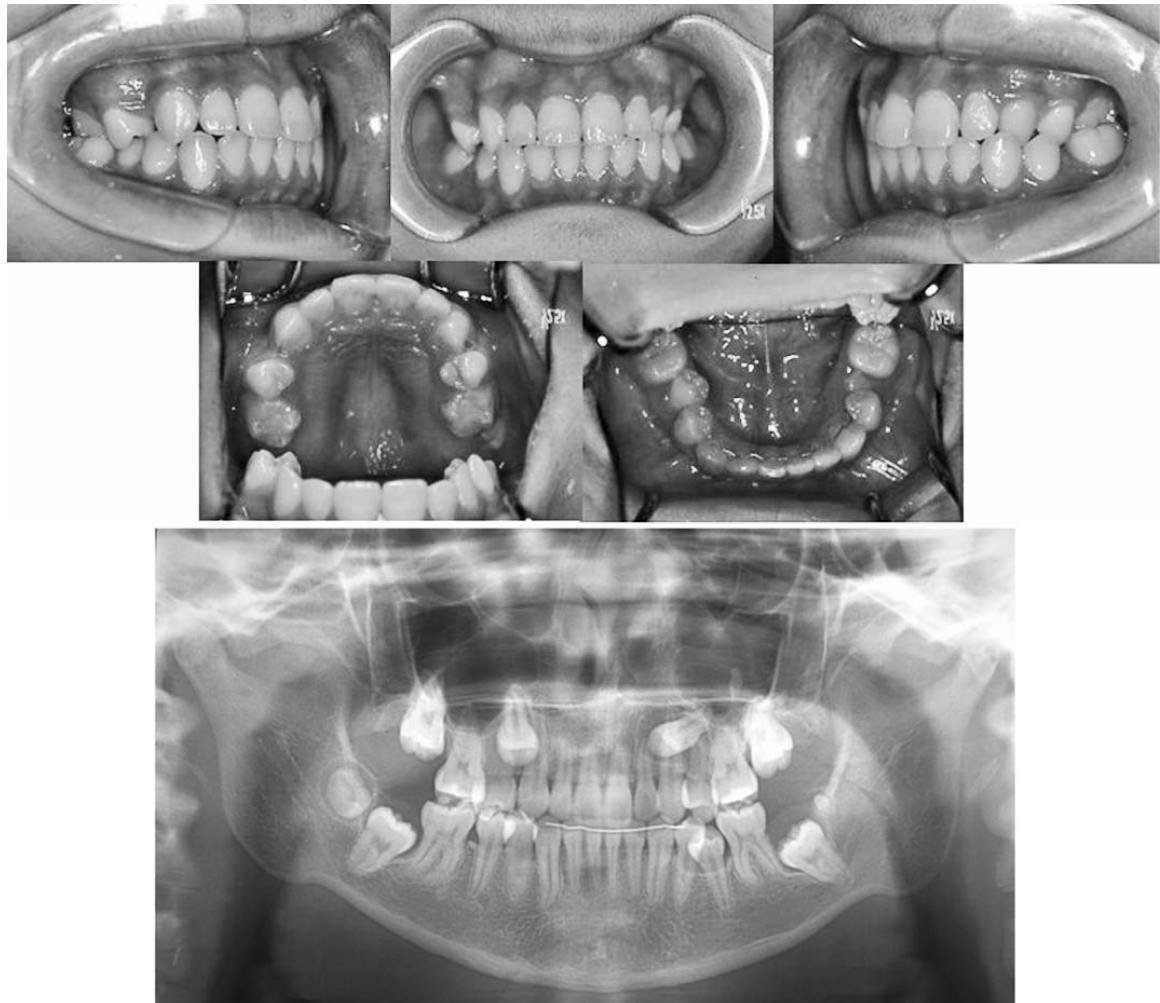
Intraoral photographs and panoramic radiograph at the age of 14 years 8 months.
